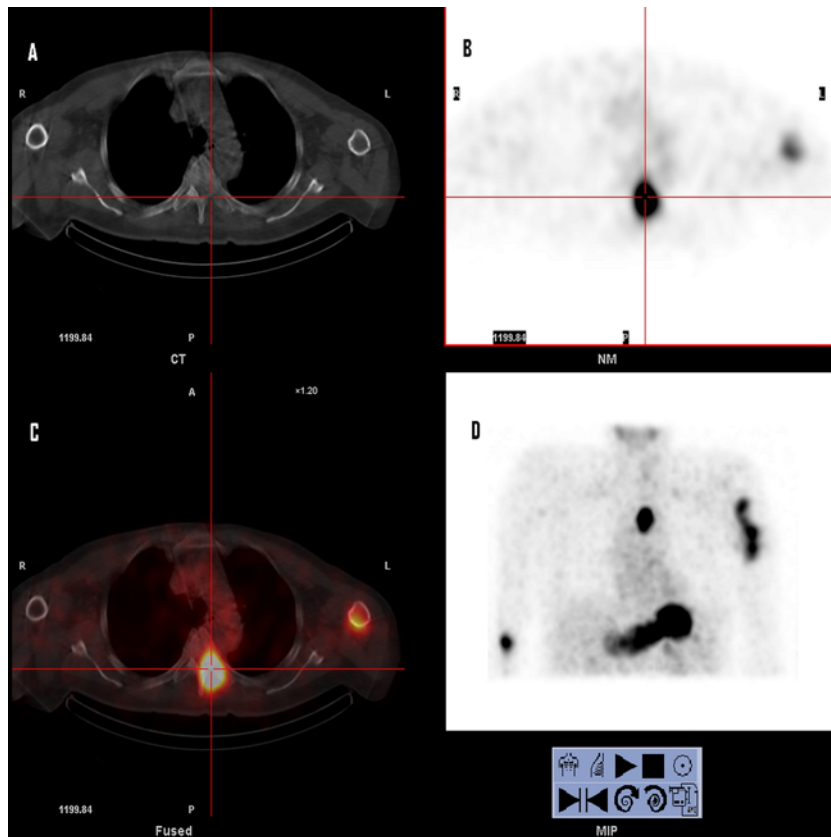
SPECT/CT fusion images showing an intense uptake located at a lytic area of the of 5th thoracic vertebra left lamina. (A: transaxial CT image, B: SPECT image, C: fusion image, D: MIP).
